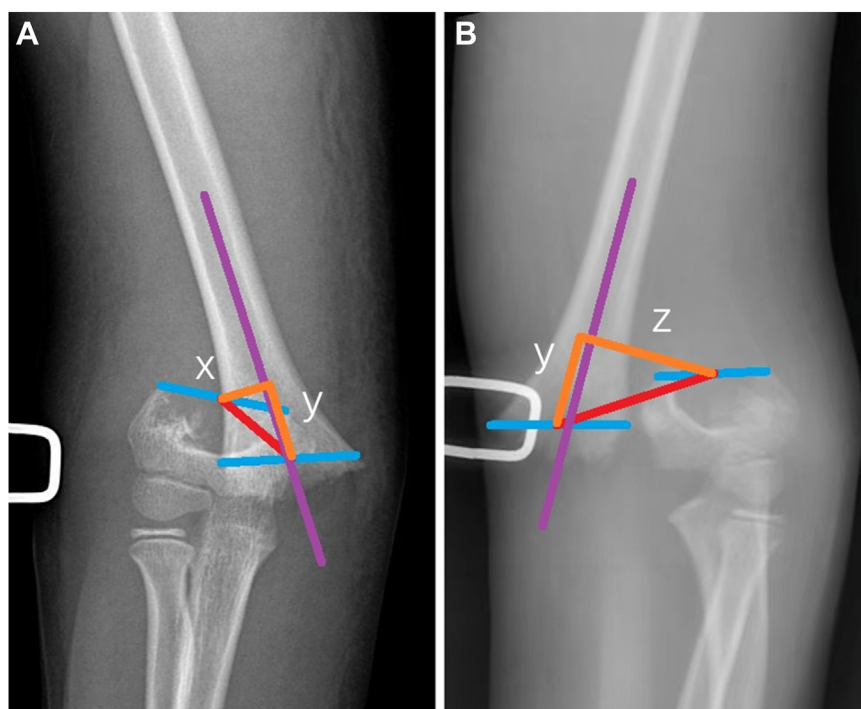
Processed values on X-ray images of a male patient (age, 9.45 years) with Gartland III supracondylar humerus fracture. (A and B) Same as [Figure 3](#).
